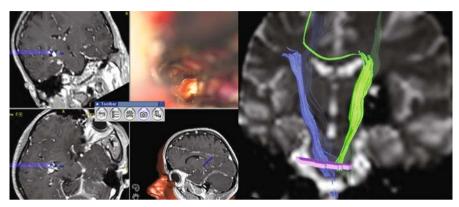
Intraoperative screen shot from the neuronavigation monitor (*left*). Neuronavigation played an important role in determining the optimal trajectory through the posterior Sylvian fissure to reach the lesion in this specific case. The corticospinal tract is shown on preoperative MRI with fiber tracking to be located medial to the lesion with a slight lateral-to-medial shift
